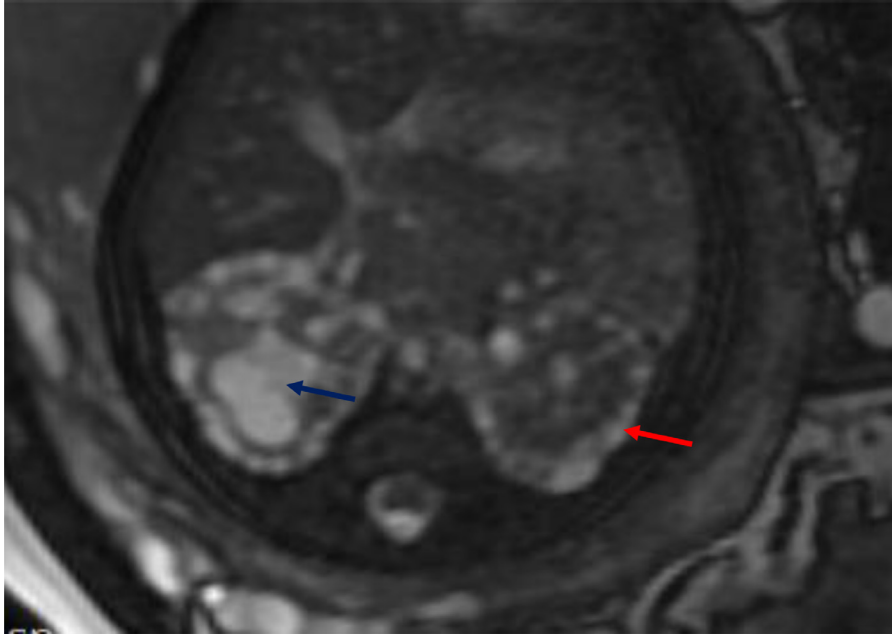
Axial T2 FIESTA fetal MRI at 35 wk GA at the level of the kidneys demonstrate enlarged kidneys with innumerable tiny cysts along the cortex (red arrow). Hydronephrosis is also seen within the right kidney (blue arrow). GA, gestational age. “Color version available online.”
